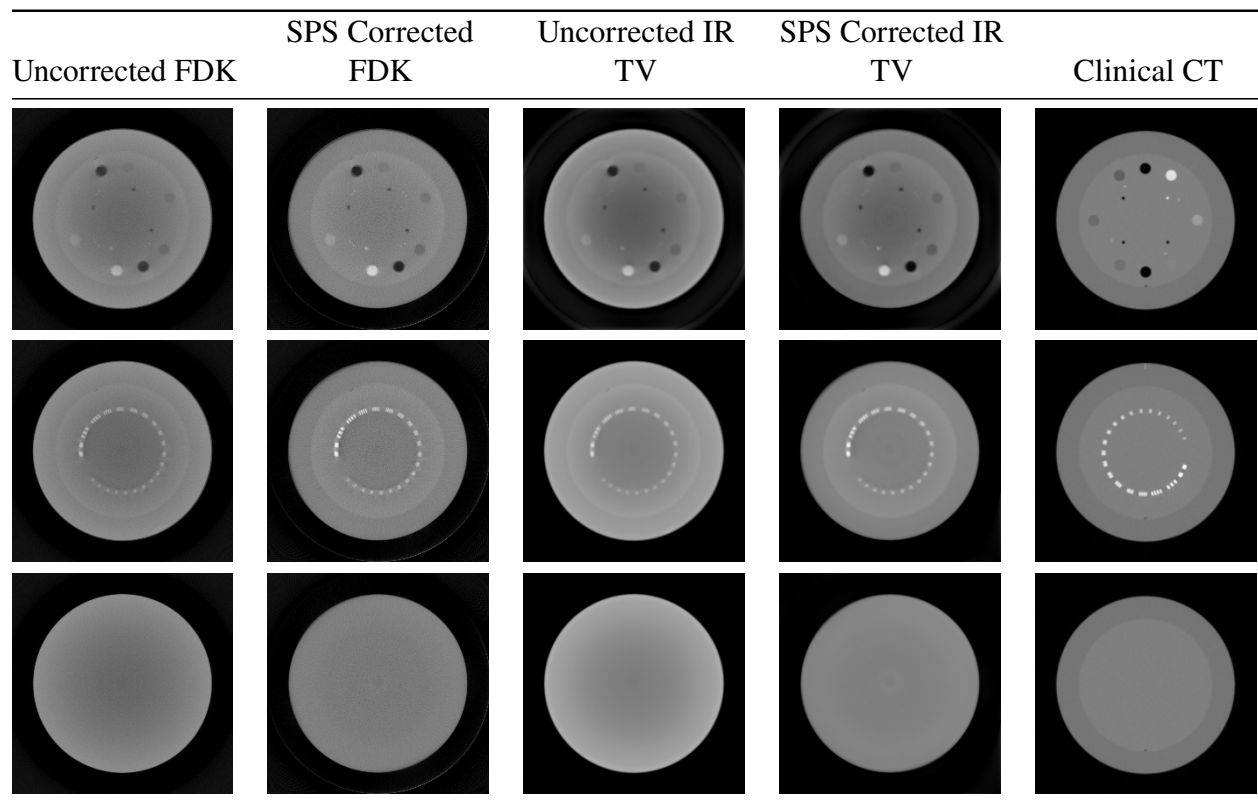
Reconstruction comparison across uncorrected FDK, SPS corrected FDK, uncorrected IR TV, SPS corrected IR TV, and clinical CT.
